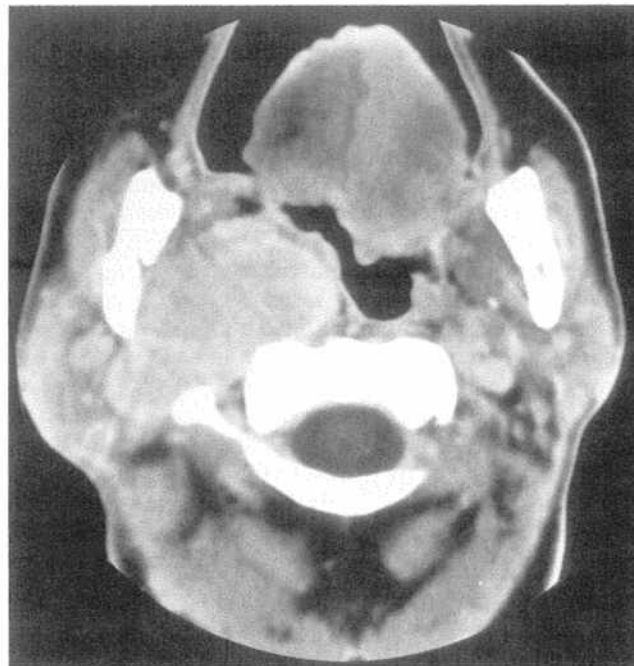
Computed tomographic scan shows enhancing large retrostyloid vagal neurilemmoma.
